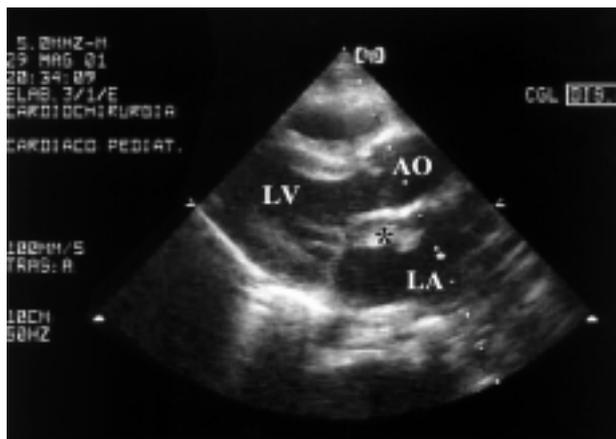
Transsthoracic parasternal long-axis view showing the mass (*) in the left atrial cavity close to the interatrial septum. AO = aorta; LA = left atrium; LV = left ventricle.
